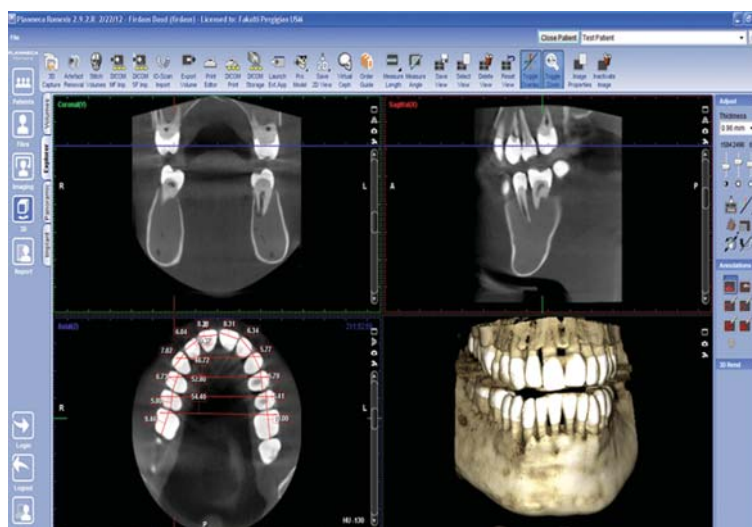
CBCT measurement via Planmeca Romexis software.
